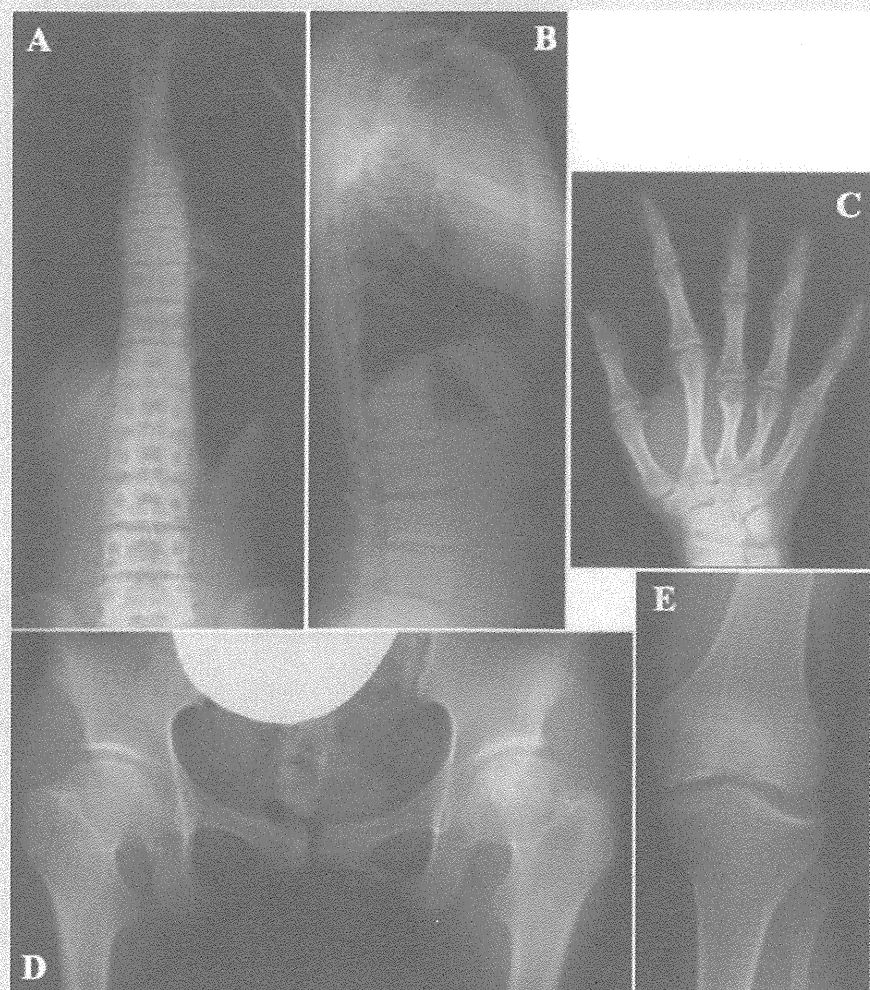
Radiographs of Patient 2 at age 14 years compatible with spondyloepimetaphyseal dysplasia Maroteaux type. A,B: Spine A-P (A) and lateral (B). Slightly flattened vertebral bodies with irregular vertebral plates and narrowing of the intervertebral disc spaces. C: Hand A-P, brachydactyly. D: Pelvis A-P. Dysplastic changes in the hips, including short femoral necks with flattened capital femoral epiphyses. E: Knee A-P. The epiphysis is dysplastic, flattened, and irregular.
